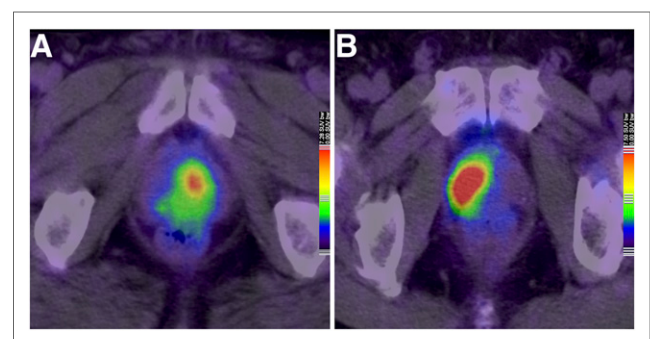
Different PSMA tracer uptake according to GS: 1 patient with GS 6 prostate cancer and SUV_{max} of 7.33 (A) compared with a GS 9 tumor and SUV_{max} of 16.64 (B).
